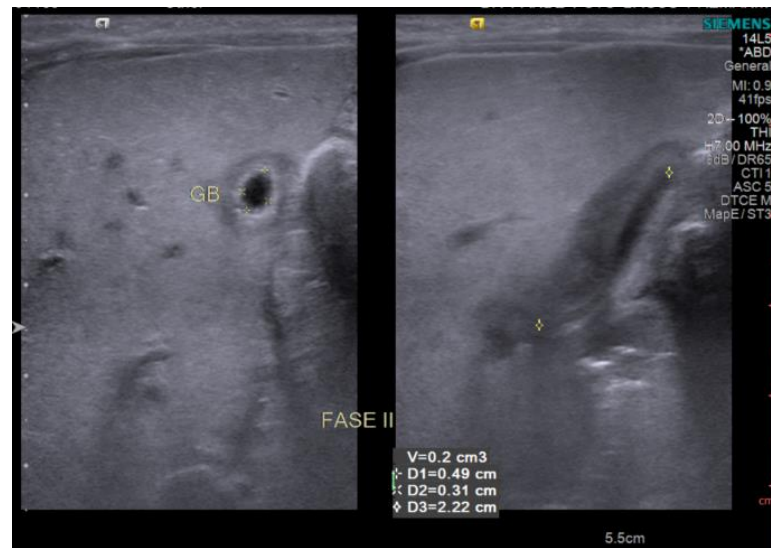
Results of 2-phase abdominal ultrasound on the 15th and 18th day of treatment.
